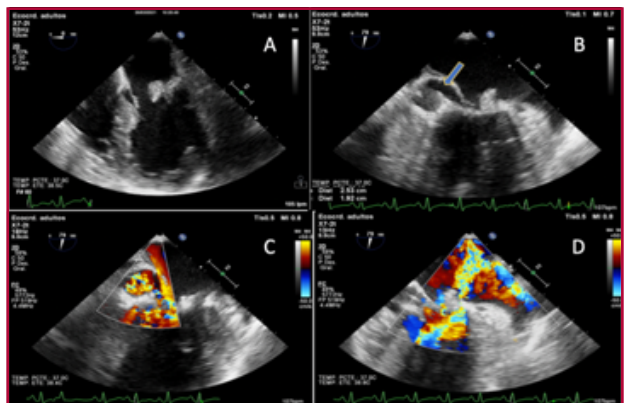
Transthoracic echocardiography. A. Valve thickening and mobile images in both leaflets; B. Pseudoaneurysm of the posterior mitral leaflet, with 2.53 cm × 1.92 cm diameter (blue arrow); C. Abnormal turbulent flow inside the pseudoaneurysm; D. Moderate mitral regurgitation.
